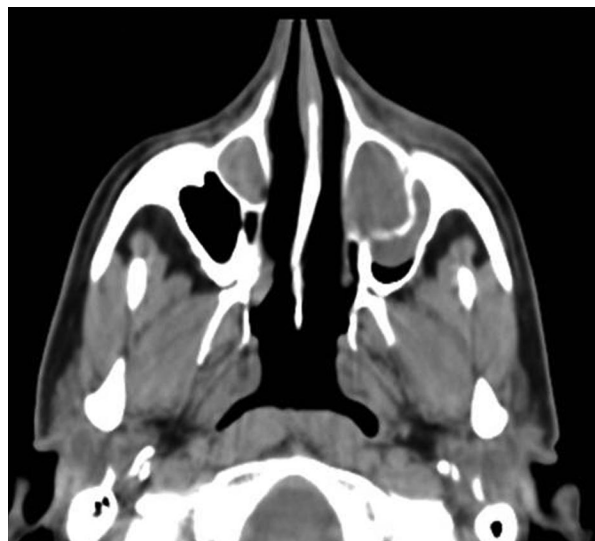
Case 1, a 39-year-old woman. Preoperative axial CT shows enlargement of both nasolacrimal ducts: 29-mm diameter on the left and 17-mm diameter on the right.
